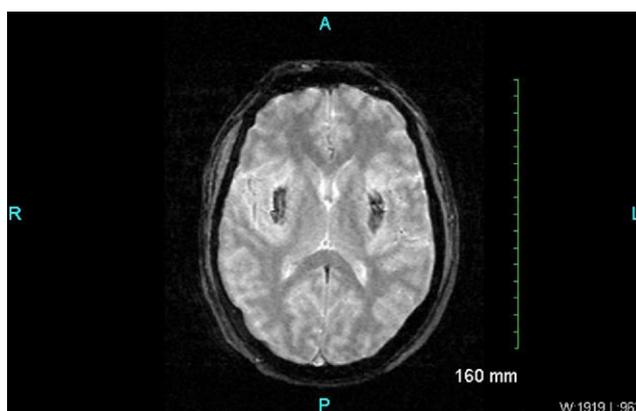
T2-weighted magnetic resonance image showing a margin of increased signal around the hemorrhage in the bilateral putaminal areas.
